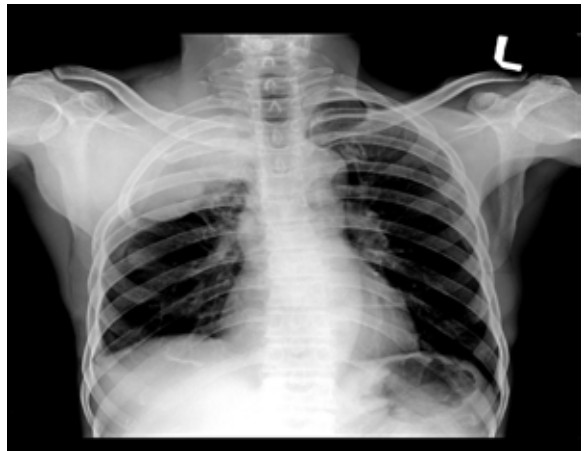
chest radiograph showing soft tissue mass in right upper chest with rib erosions.
